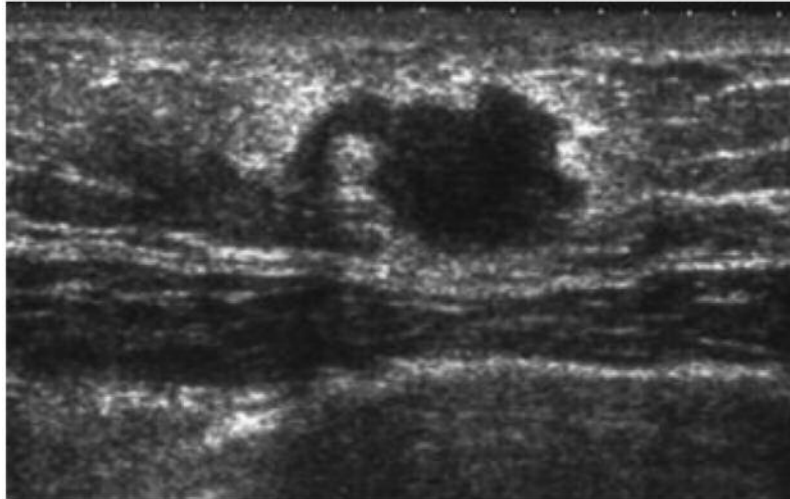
Ultrasound examination of the left breast revealing the presence of a retroareolar solid lump with a diameter of approximately 17 mm.
